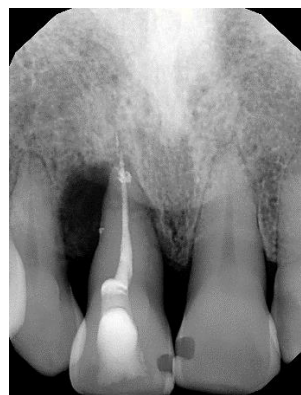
Periapical radiograph, after trauma.
